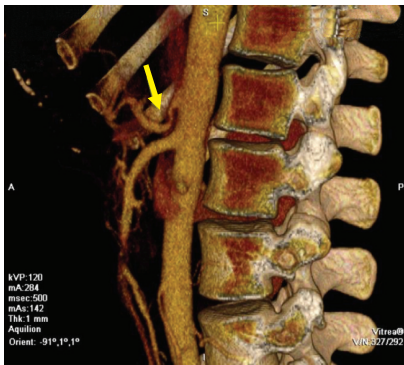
3D thoraco-abdominal CT angiography showing compression of the celiac trunk origin by the arcuate ligament (arrow) causing stenosis, and collateral venous development through the pancreaticoduodenal arcade connecting with branches of the hepatic artery.
